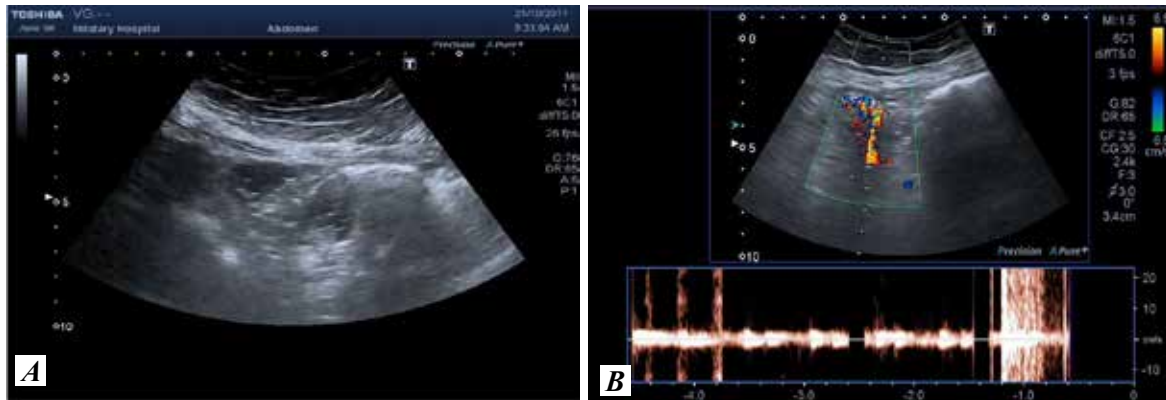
Duplex- Doppler examination of intestinal peristalsis in II group patients with developing post-operative mechanical intestinal obstruction
